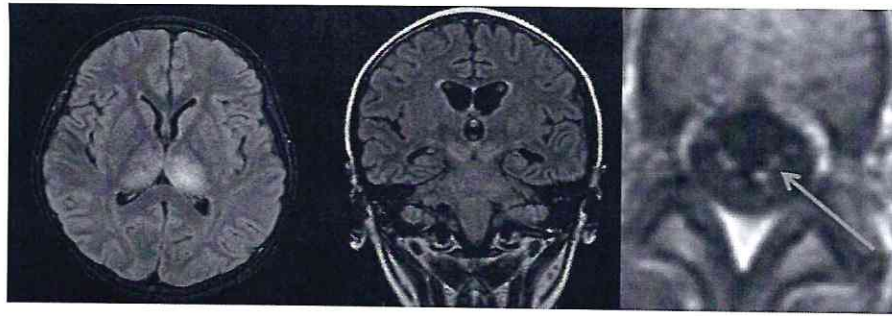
Magnetic resonance images. (Left) Initial sagittal T2-weighted/fluid-attenuated inversion recovery (FLAIR) sequence, which reveals increased signal in the bilateral thalami. (Center) Follow-up coronal T2-weighted/FLAIR sequence 45 days after the transplant, which shows increased T2-weighted signal in the bilateral midbrain, including the cerebral peduncles, entire midbrain dorsally, pons, and portions of the medulla, especially ventral. (Right) Abnormal nerve root enhancement.
